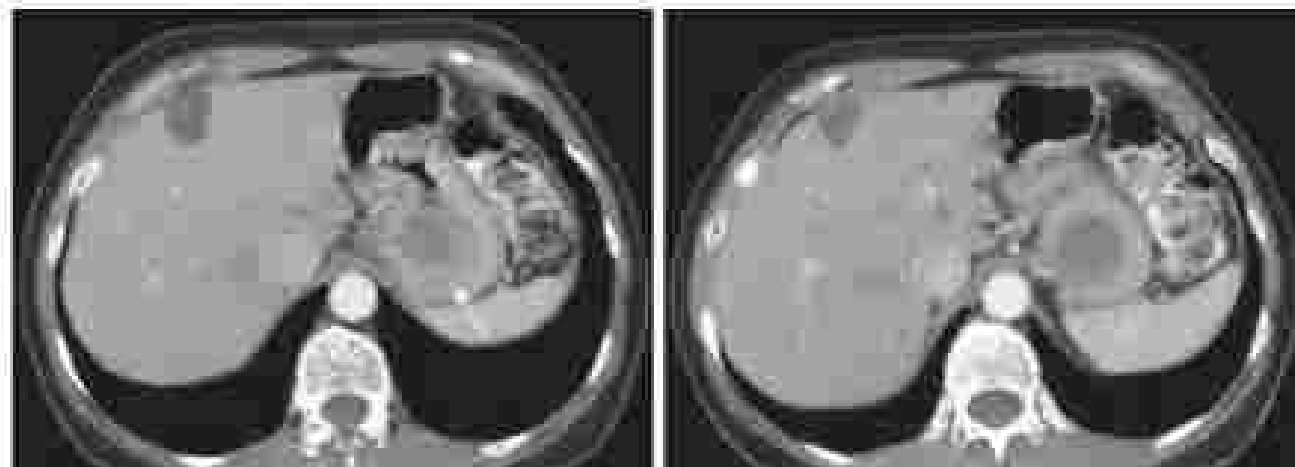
Contrast-enhanced computed tomography scan of a patient with a gastric gastrointestinal stromal tumor that is imatinib responsive and located along the junctional aspect of the gastric folds just 3 cm beyond the gastroesophageal junction (arrow). Open windows with routine gastroenterography is recommended for tumors in the stomach.
